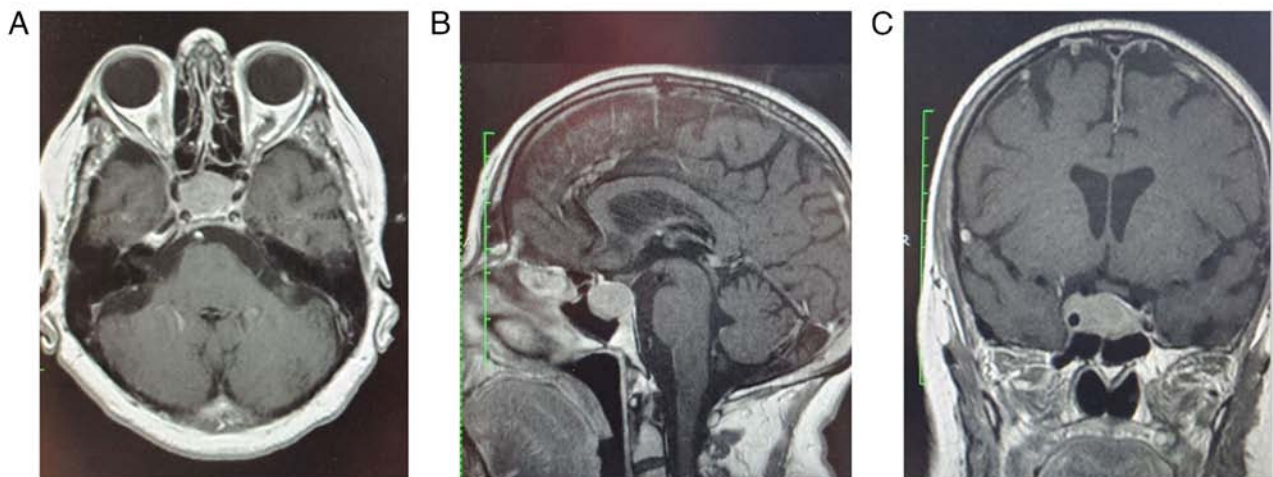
(A-C) Pre-operative contrast enhanced T1 MRI scan of patient 6, depicting a pituitary macroadenoma.
